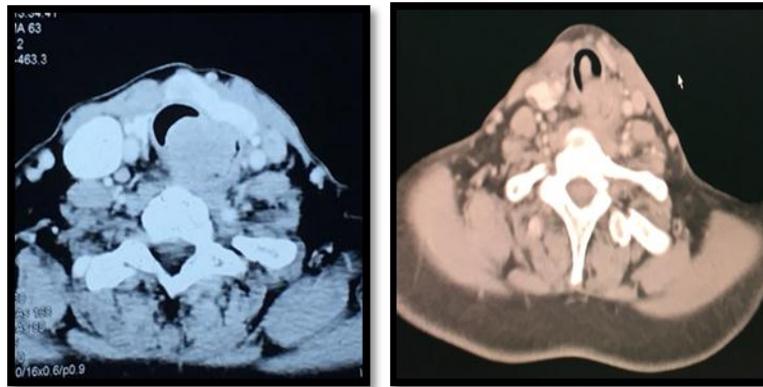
cervical CT-scan showing an infiltration of the trachea by the tumor.
